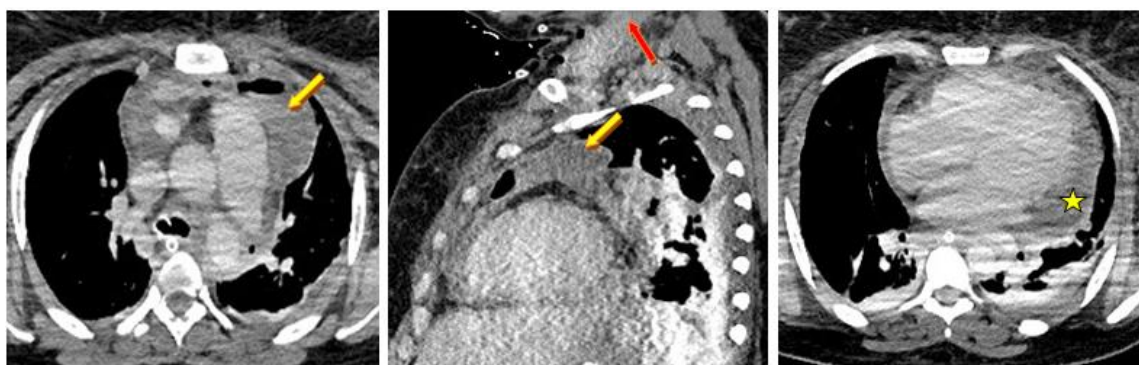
Cervico-thoracic CT scan upon admission showing diagnosis of mediastinitis: anterior mediastinal (yellow arrows) and cervical (red arrow) collections + pericardial effusion (yellow star)
